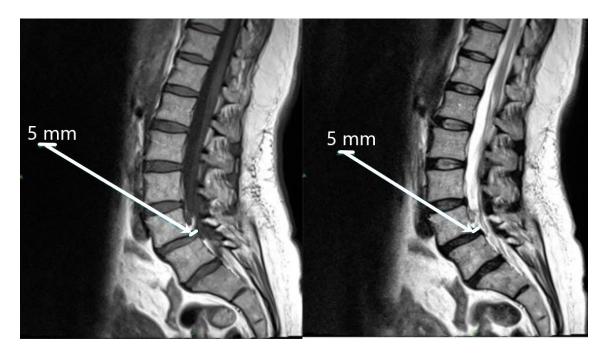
Spondylolisthesis on MRI.
